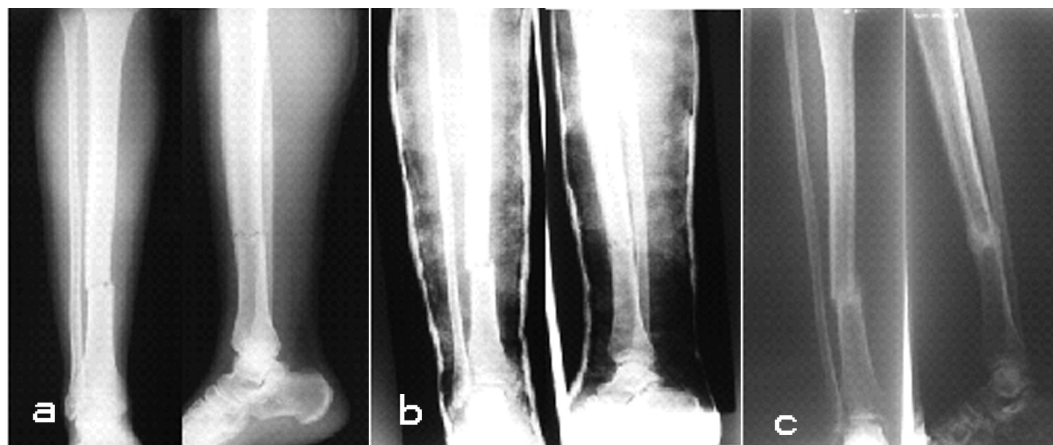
Case1: 19 years old male, (a) initial radiography, type A3.1 (b) after casting, (c) after 4 months, 10° varus and 3° posterior bowing.
